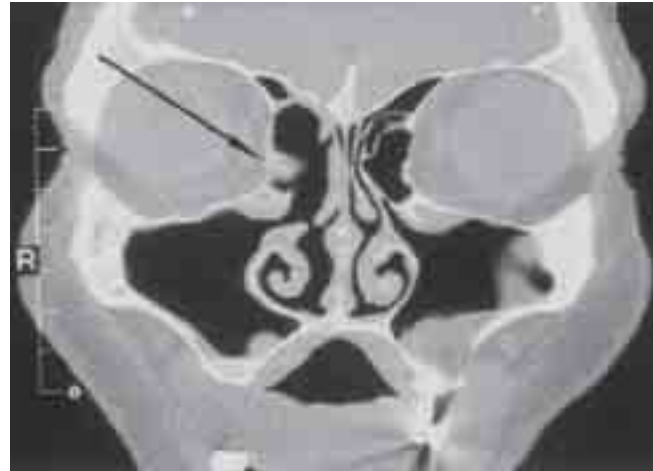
Patient A: Post-operative coronal CT scan view showing bone reconstruction (black arrow), and ethmoid, maxillary sinuses free of disease.
